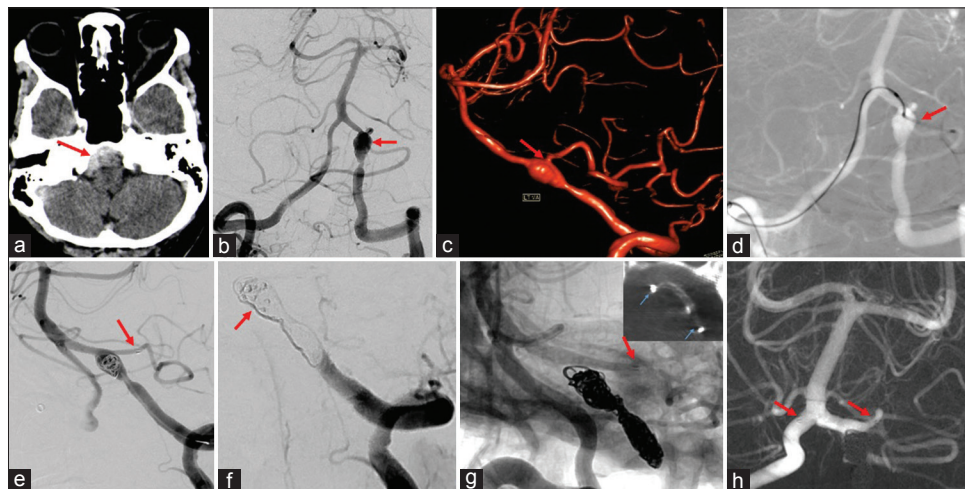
(a) Acute subarachnoid hemorrhage (arrow) on cranial computed tomography. (b and c) Two-dimensional and 3-dimensional rotational angiography respectively showed the vertebral artery dissecting aneurysm extending to the origin of left posteroinferior cerebellar artery (arrow). (d) Microcatheter placement into the left VA from the right VA (arrow). (e) Stent placed (arrow) into the left posteroinferior cerebellar artery. (f) Coil embolization of dissecting aneurysm. (g) Stent (arrow) in left posteroinferior cerebellar artery and well opened stent on Dyna computed tomography in image box. (h) Six-month follow-up angiography revealed occluded aneurysm with normal opacification of left posteroinferior cerebellar artery
